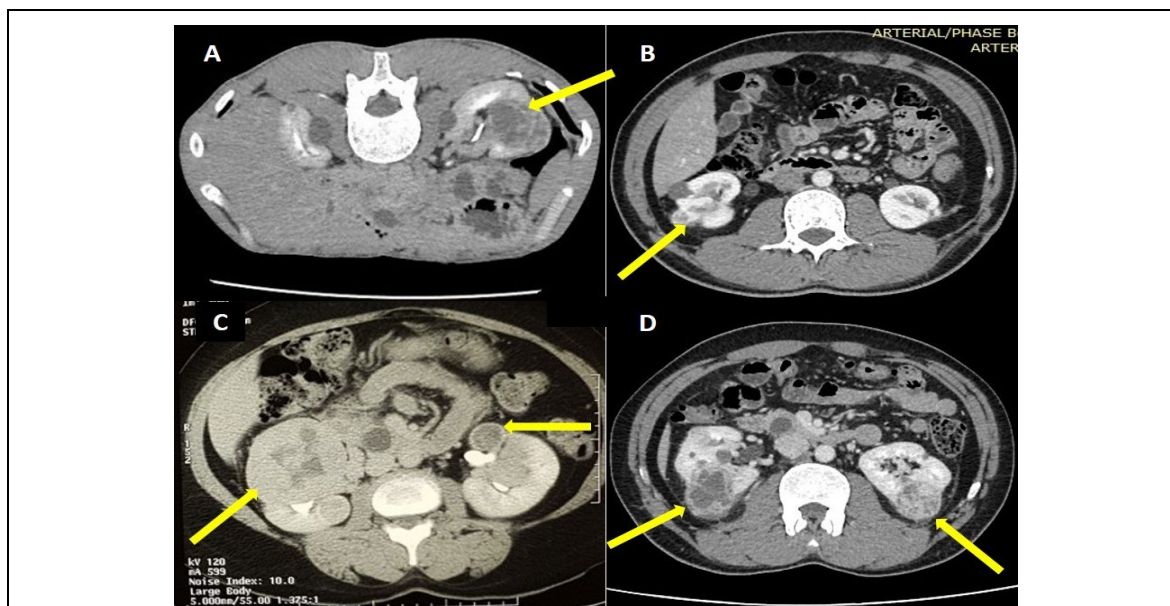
Computed tomography images showing multiple renal tumors (arrow) of patients 6, 2, 5, and 3 are shown in (a-d) respectively.
